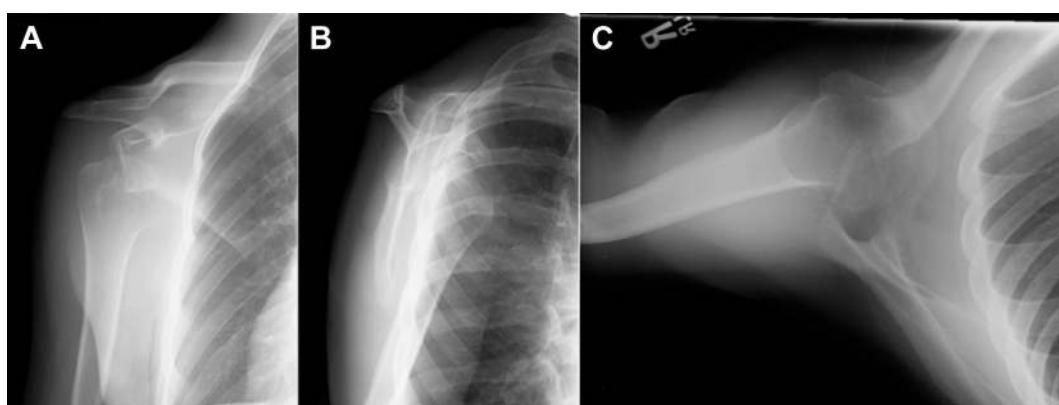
(A) Anteroposterior, (B) scapular Y, and (C) axillary radiographs of a right shoulder showing anteroinferior glenohumeral dislocation.
